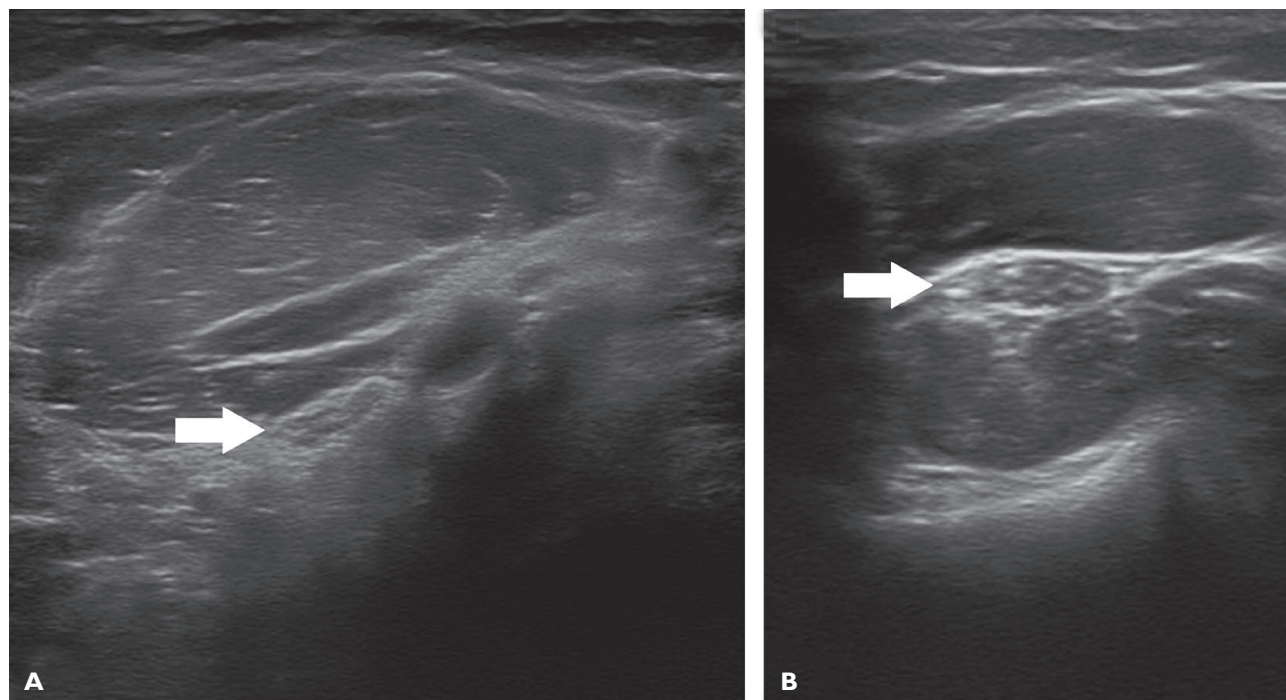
A) Ultrasonography of the left forearm demonstrating flattening of the median nerve between the muscle bellies of the humeral and ulnar heads of the pronator teres (white arrow). B) Ultrasonography of the left forearm at the level of the radial head, demonstrating a normal-looking median nerve (white arrow).
